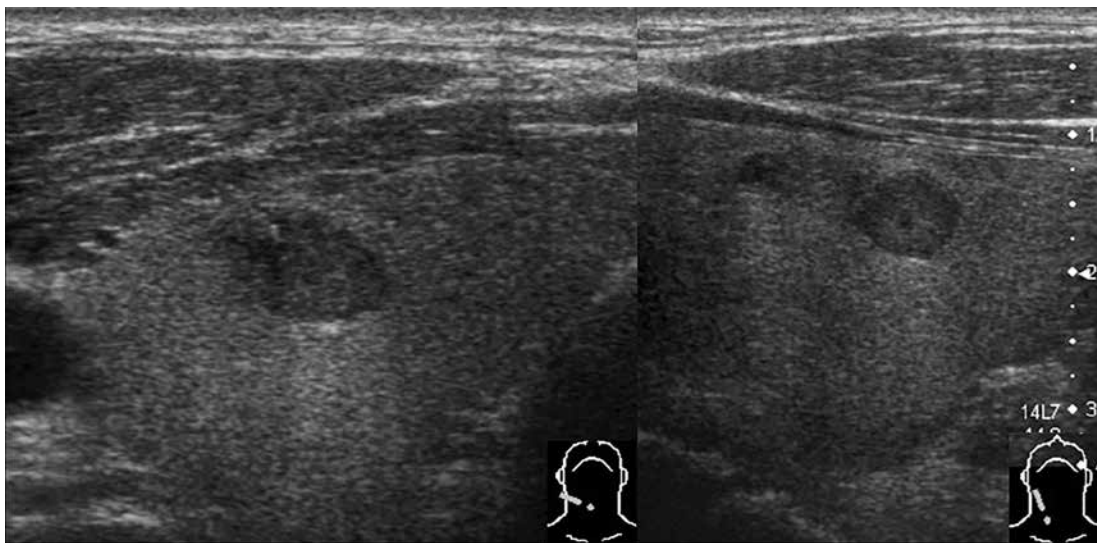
Ultrasonography revealed the presence of a 6.3 x 8.3 x 9.2mm nodule in the middle of the right lobe.
